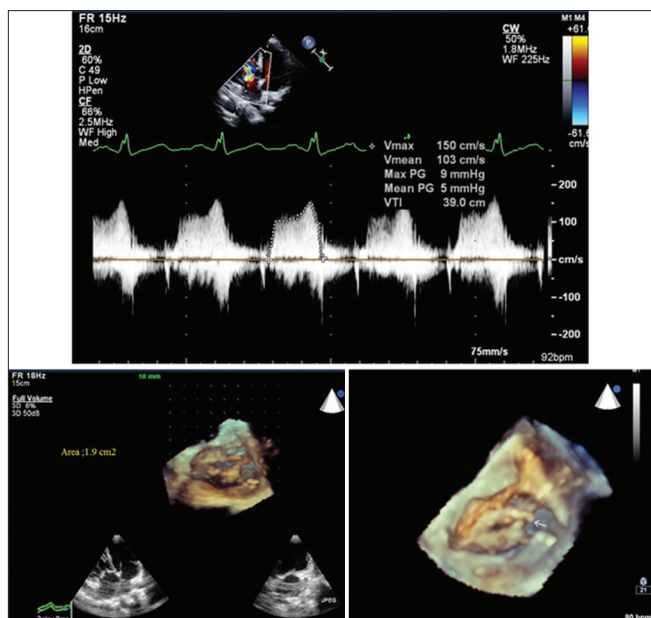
Post-procedure echocardiography: Two-dimensional echocardiography showing a gradient of 9/5 mmHg across the systemic atrioventricular valve. Three-dimensional echocardiography depicting a valve area of 1.9 cm² with split of one of the commissures (arrowhead)
